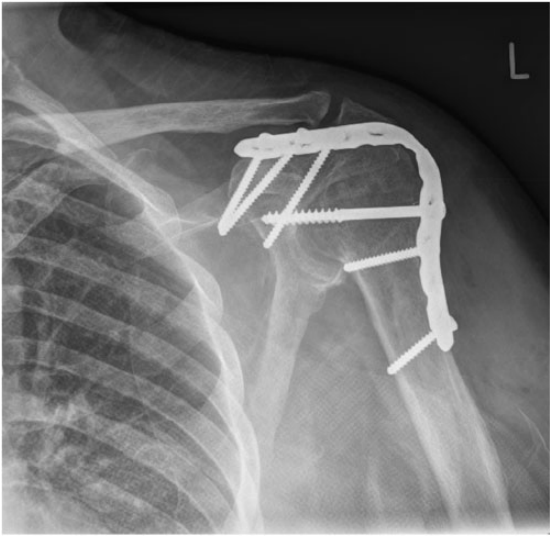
Anteroposterior radiograph of an 80-year-old right, hand-dominant female, 2 months after left glenohumeral arthrodesis using a locked compression plate (DePuy Synthes).
